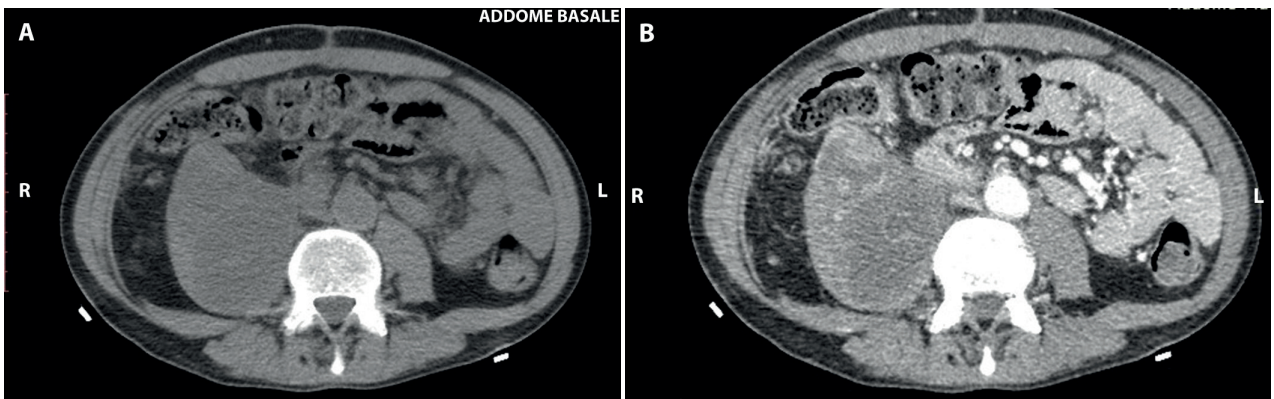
Follow-up CT scans demonstrate a heterogeneous hypodense mass in the right paravertebral side; (A): axial unenhanced CT scan, (B): axial enhanced CT scan.
